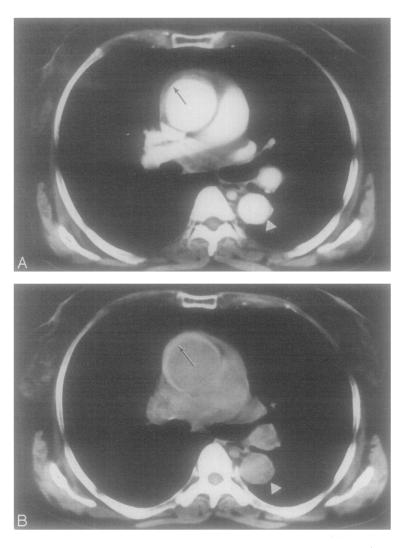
Admission CT scan from patient #7 with (A) and without (B) intravenous contrast administration. A large hematoma surrounding ascending aorta is evident (black arrow). Note that descending aorta appears normal at this time (white arrowhead).
